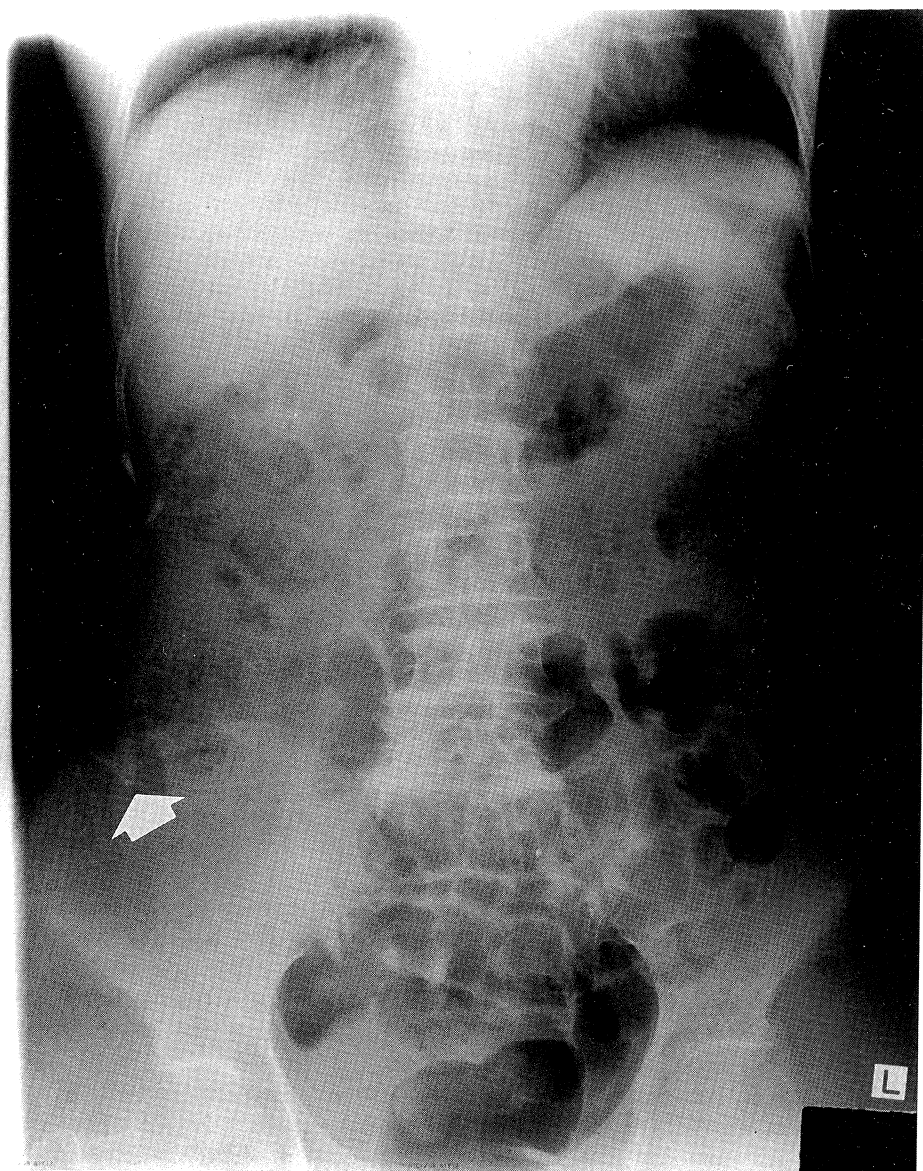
Plain x-ray examination of the abdomen did not suggest bowel obstruction or perforation. The distal end of the shunt tube was located in the right lower abdomen. (white arrow)
